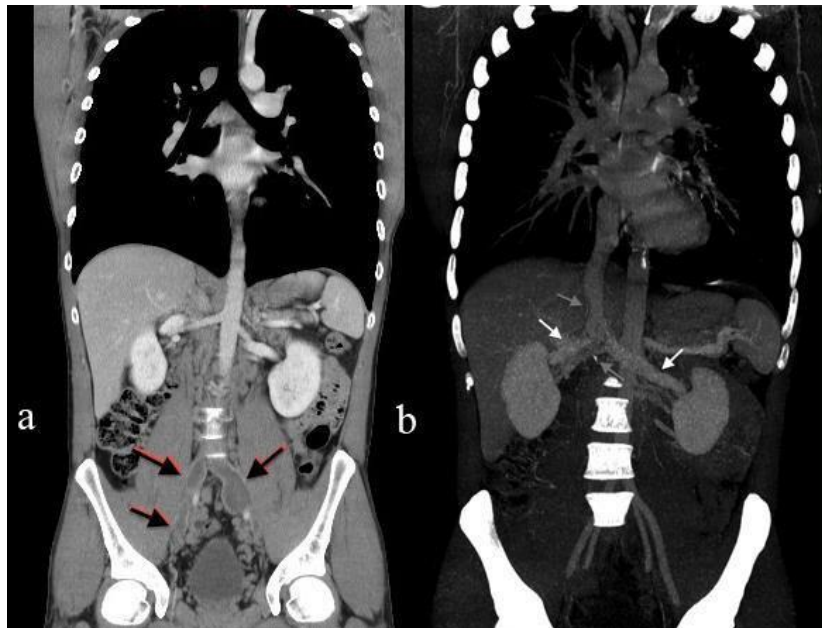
Figure caption: CT image (*sagittal section*) Inferior vena cava agenesis (Figure 1b grey arrow), increased lumbar paravertebral collateral circulation and pelvic varices (Figure 1a black arrow) and unaltered renal veins (Figure 1b white arrow).
